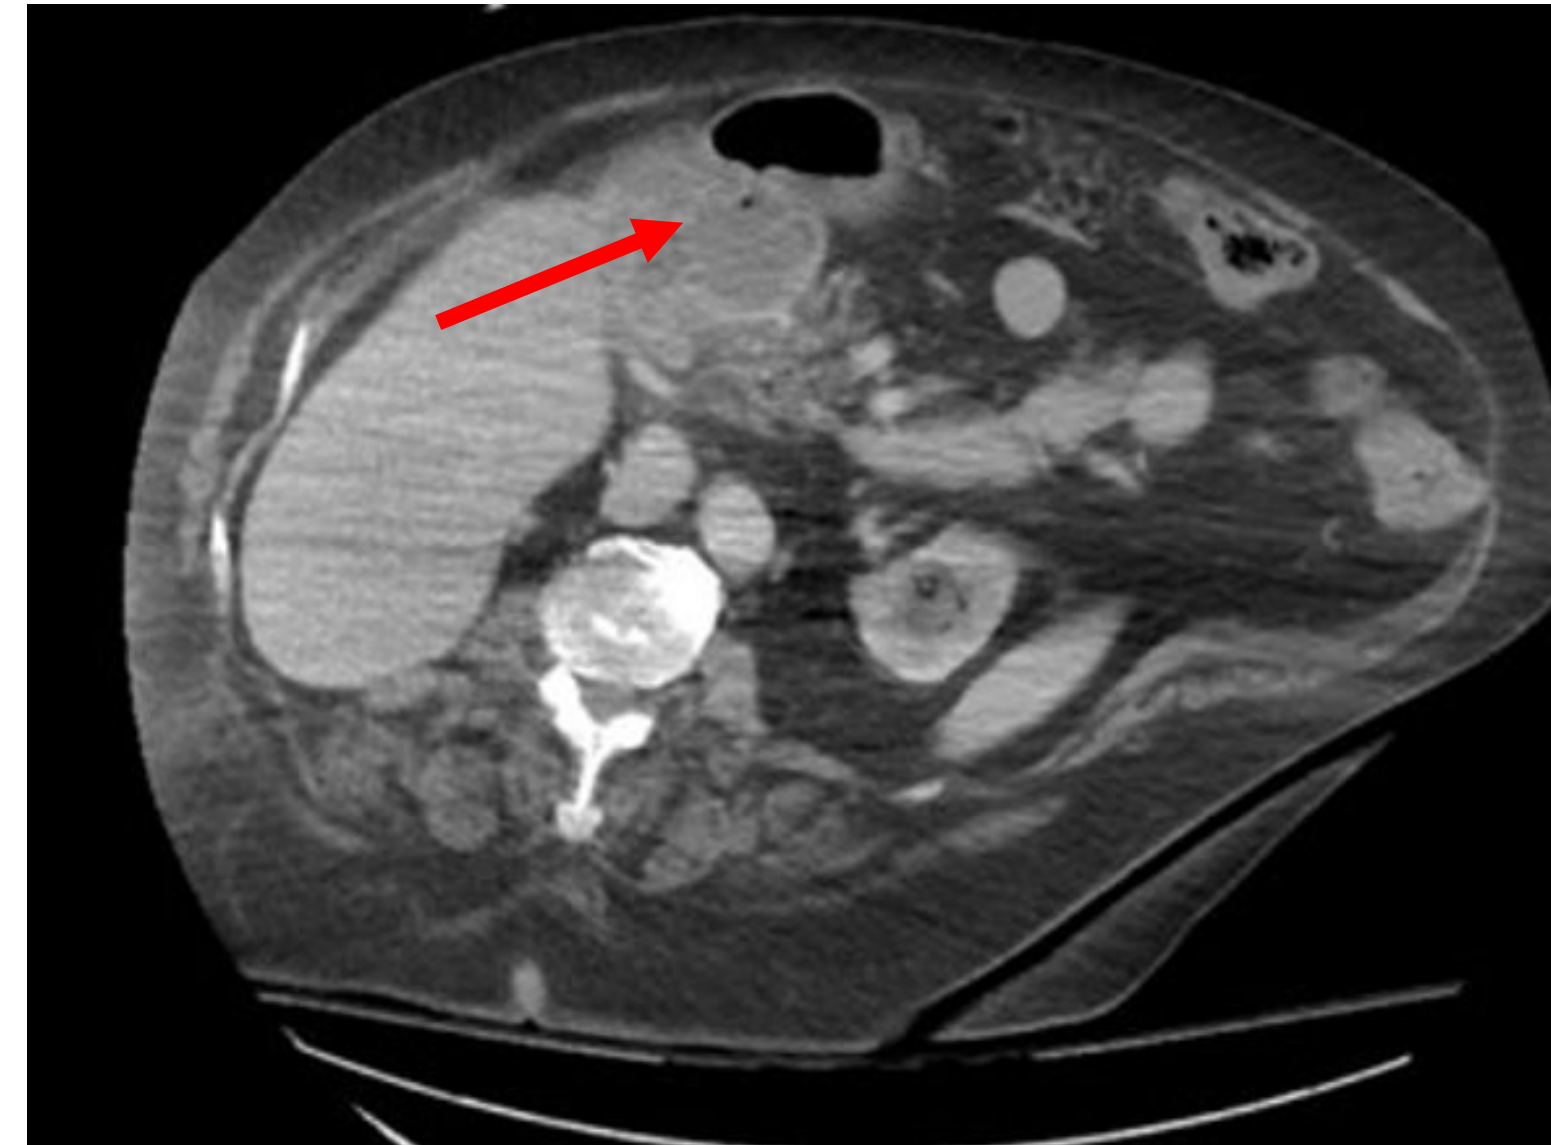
Abdominal CT demonstrating choledochoduodenal fistula and associated abscess
